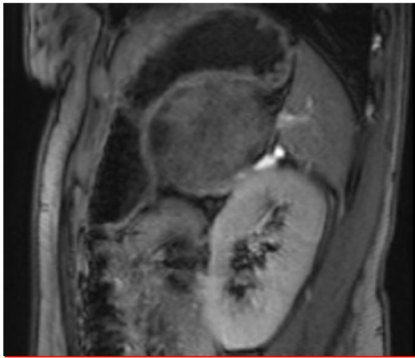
MRI: A pancreatic tail mass, adjacent to the spleen hilum.
